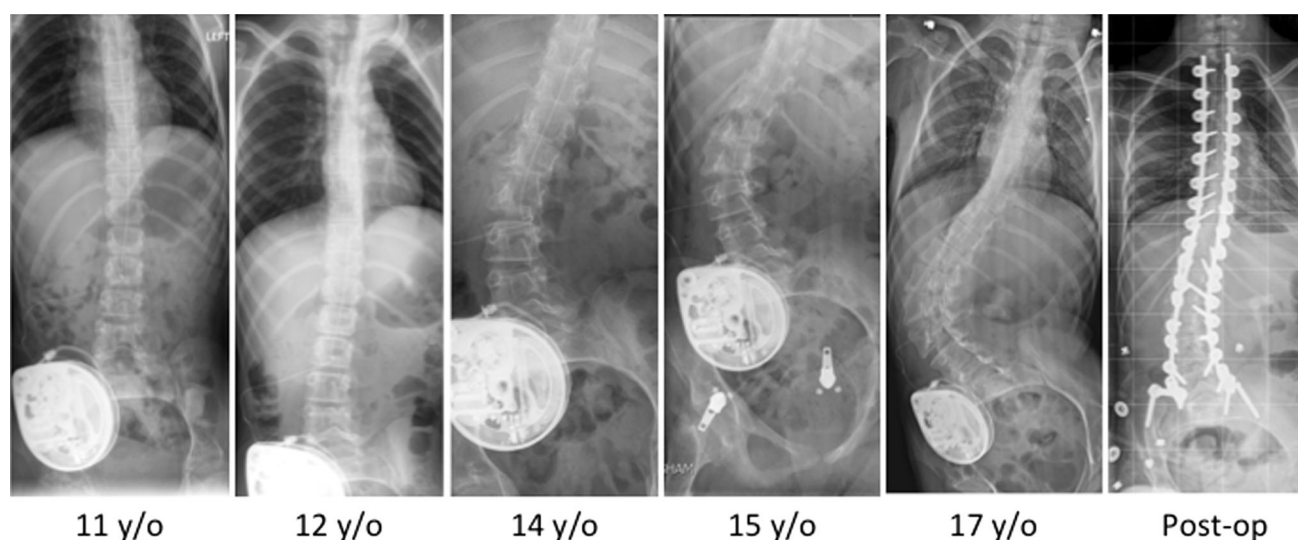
Spine radiographs showing a progressive scoliosis from the age of 11 years to the age of 17 years, resulting in a curve of 86° from T11 to L4. The final sitting radiograph was performed at 6 months following surgery and shows correction of scoliosis to 24° from T11 to L4
